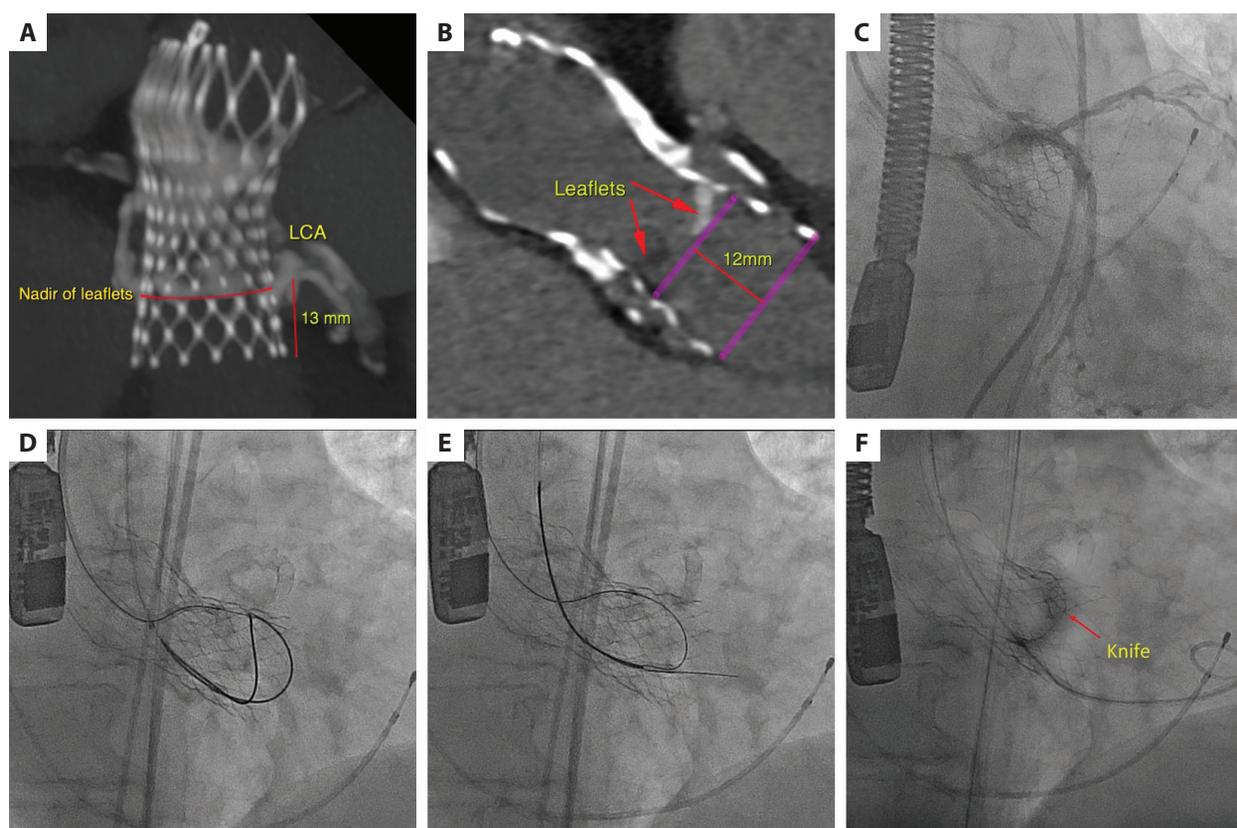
A–B. The coronary artery and CoreValve cusps on computed tomography. C. Coronary artery flow after the transcatheter aortic valve replacement (TAVR-in-TAVR). D. BASILICA technique: puncture of the leaflet. E. BASILICA technique: wire snaring. F. BASILICA technique: laceration of the leaflet
